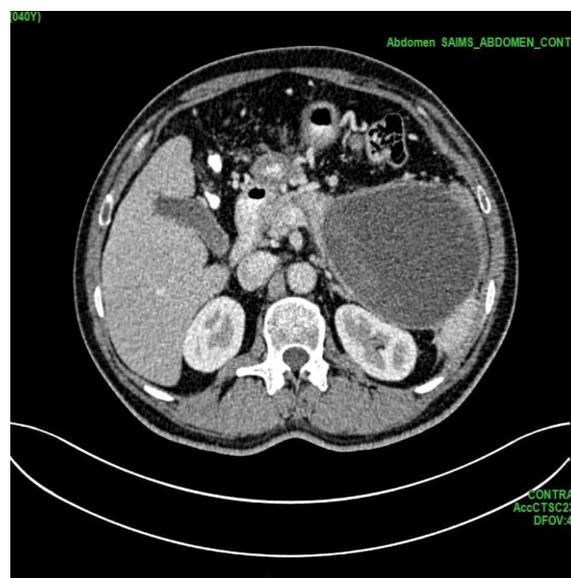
Axial contrast-enhanced computed tomography scan of a 41-year-old male patient with retroperitoneal large pancreatic pseudocyst, well defined thin enhancing walled cystic lesion with few areas of hyperdense contents inside seen arising from the body and tail region of pancreas and insinuating into the lesser sac. The lesion is abutting the spleen with maintained fat planes, causing compression over the left renal and suprarenal gland and displacing the bowel loops
